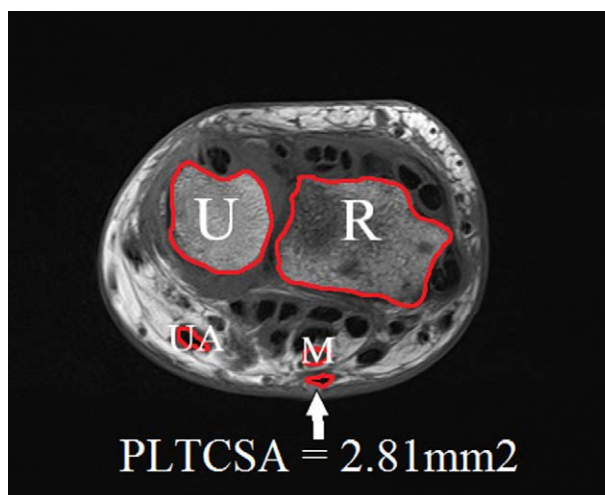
Axial T1 weighted turbo spin echo wrist MR images of the PLTCSA at the pisiform level. M = median nerve, PLTCSA = palmaris longus tendon cross-sectional area, R = radius, U = ulnar, UA = ulnar artery.
